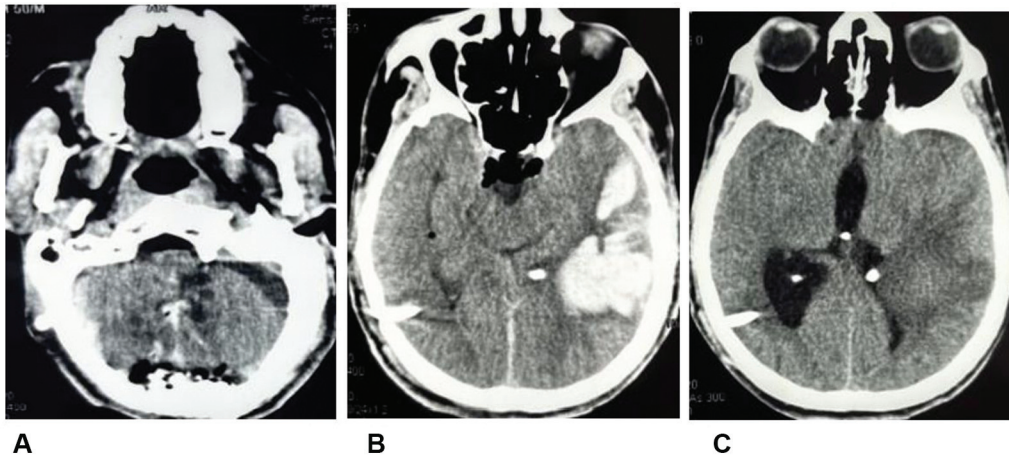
Postoperative plain computed tomography brain axial image (A) showing total excision of tumor, (B) left temporal intracerebral hematoma with right-sided shunt tube in situ, and (C) resolving hematoma in left temporal region.
